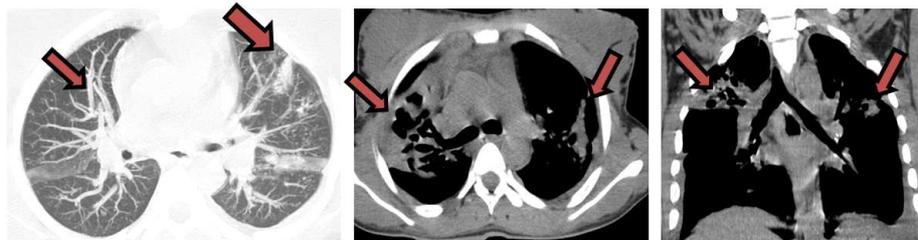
axial CT view in MINIP, showing a lesion mixture made of micronodules and condensations, image 5: axial CT view in mediastinal filter without PC injection, showing bronchiectasias in the right LS, image 6: coronal CT view in mediastinal filter without PC injection, showing an upper bi-lobar involvement
